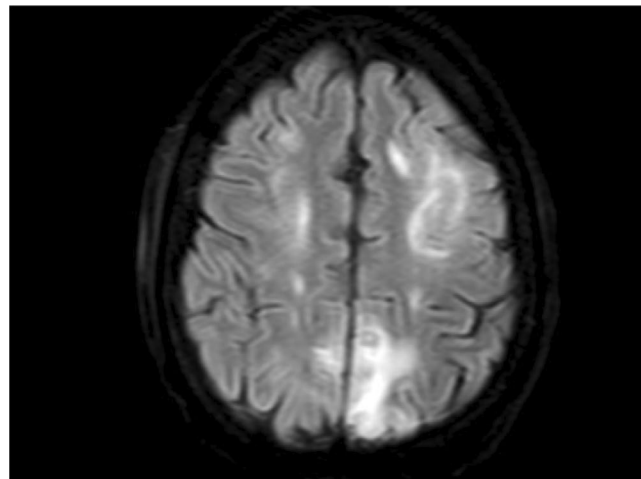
Bilateral parasagittal hypersignal noted, FLAIR.
